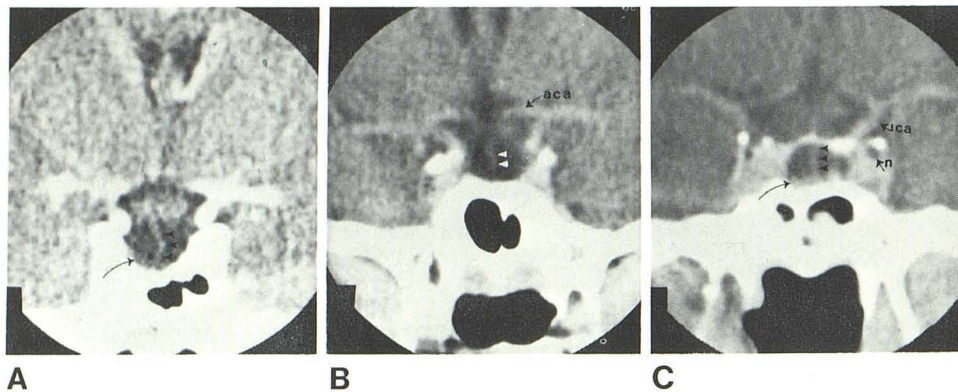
Coronal CT images. Infundibulum (arrowheads) in three patients with empty sella is traced from hypothalamus to pituitary gland (arrows). Third cranial nerve (n) in cavernous sinus and internal carotid (ica) and anterior cerebral (aca) arteries.
